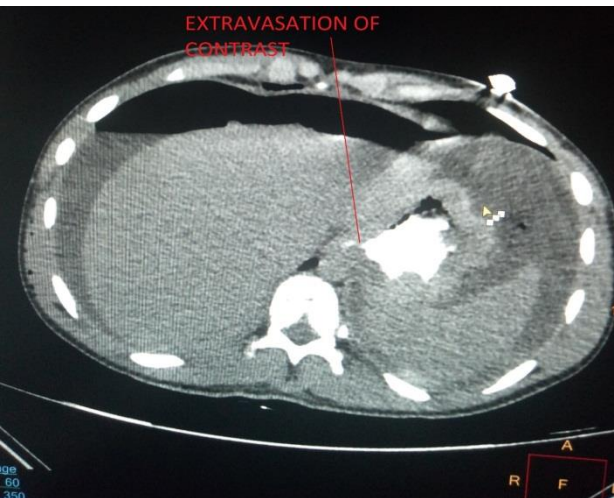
CT scan showing extravasation of contrast through stomach.
